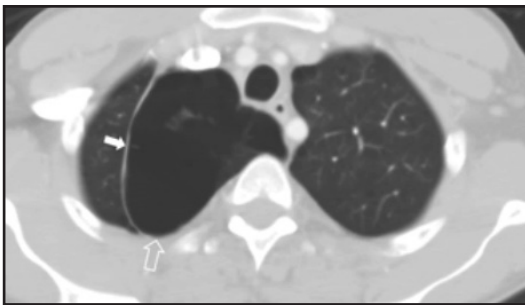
Bulla. Axial contrast-enhanced CT image demonstrating a large bulla (hollow arrow) occupying the azygos lobe (solid arrow).
